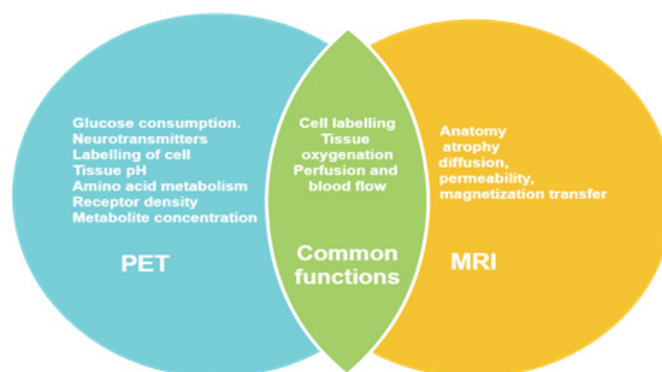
The functions of dual modality (PET/MRI) complement each other and can be acquired simultaneously.
